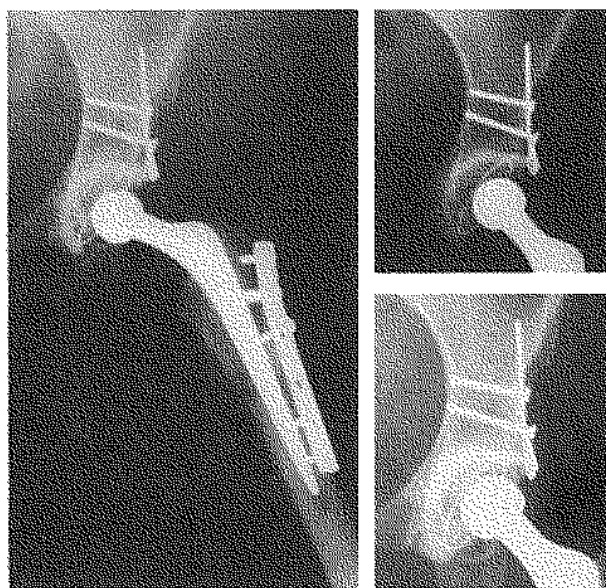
Postoperative radiographs of the one case with demarcation of the socket : (a) 3 days, (b) 14 months and (c) 4 years 3 months postoperative films : the socket is radiographically loose, although there is no progression of the radiolucency.
